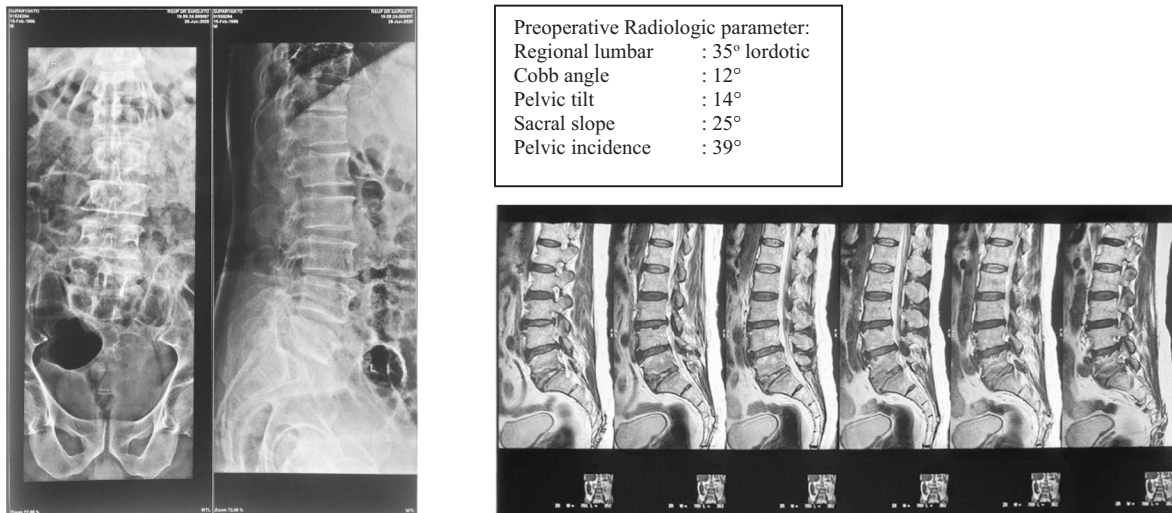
Case 6 Initial radiograph presentation.
